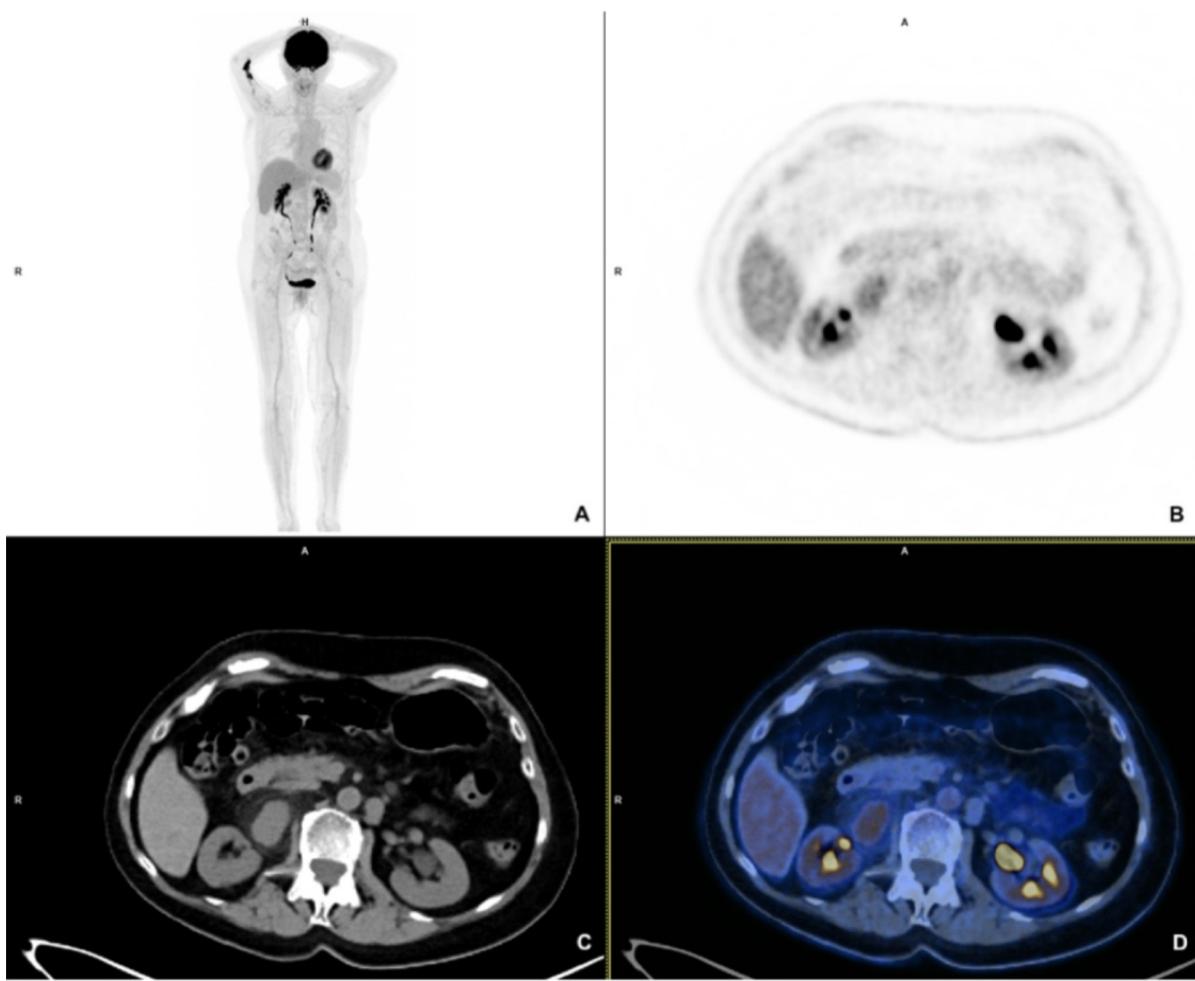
$[^{18}\text{F}]$ FDG PET/CT. (A) Whole body evaluation shows a unique lesion located near the right renal hilum. (B) PET image shows $[^{18}\text{F}]$ FDG uptake in the lesion. (C) CT image shows the anatomical location and structural features of the lesion. (D) PET/CT fusion image.
